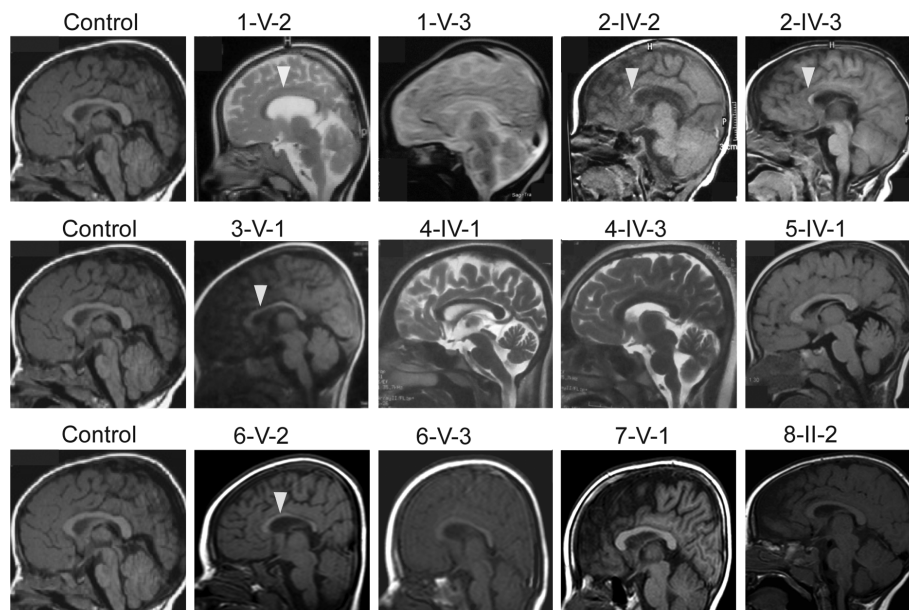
Biallelic pathogenic variants in *PCDH12* lead to defects in white matter tracts. Midline sagittal brain MRI showing thinned corpus callosum (arrowheads) in many of the affected individuals. MRI = magnetic resonance imaging.
